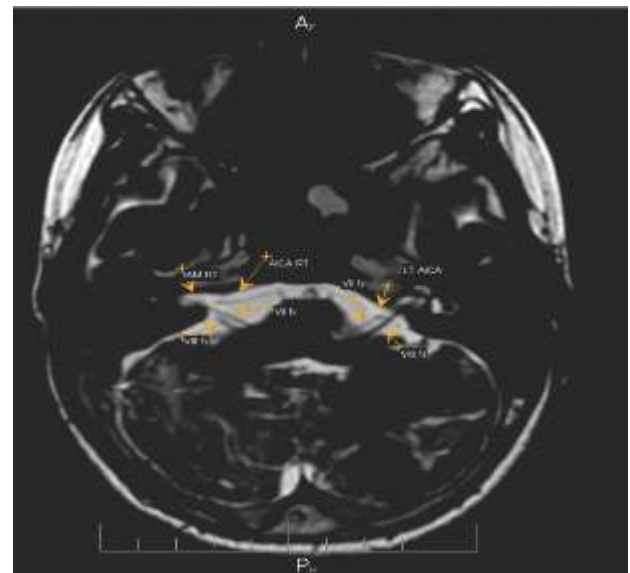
MRI 3-D FIESTA sequence axial view showing right AICA entering the IAM for less than 25% of its length (type II variant); left sided AICA loop is type I
